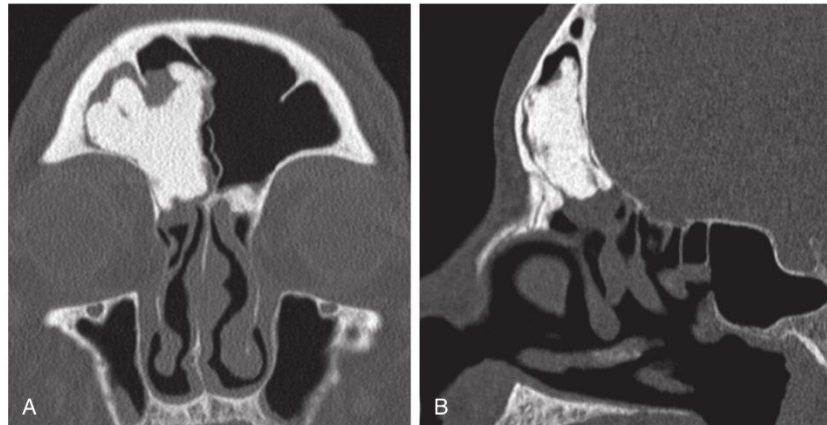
Axial (A) and coronal (B) computed tomography shows a large right frontal osteoma. In view of a large anteroposterior diameter and the presence of minimal residual space between the lesion and the surrounding wall, complete removal could be achieved through a Draf III procedure.
